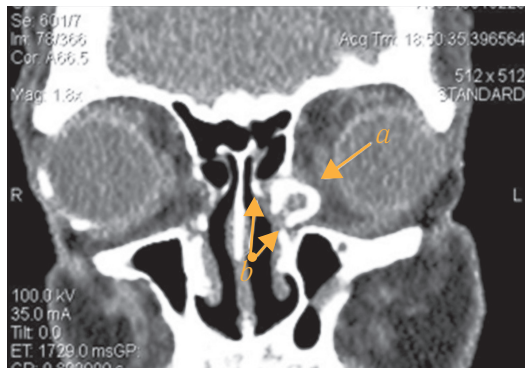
Multispiral computed tomography of lacrimal drainage system with contrast enhancement: *a* – left lacrimal sac filled with contrast; *b* – borders of the bone window
